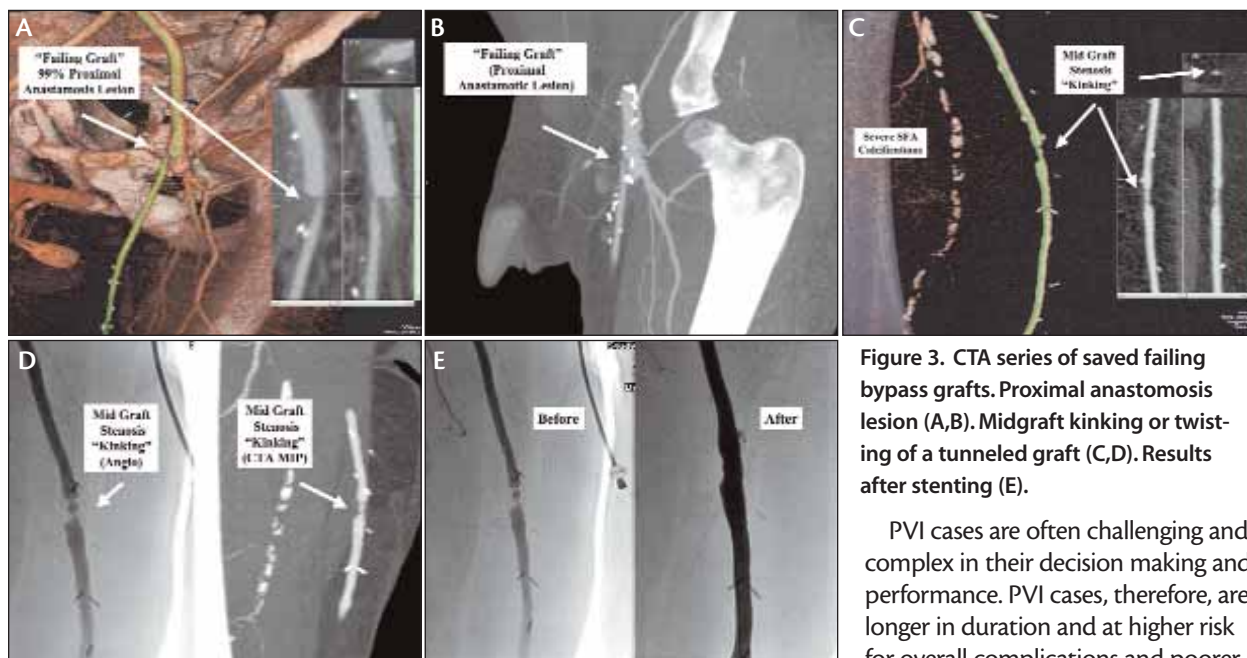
CTA series of saved failing bypass grafts. Proximal anastomosis lesion (A,B). Midgraft kinking or twisting of a tunneled graft (C,D). Results after stenting (E).
